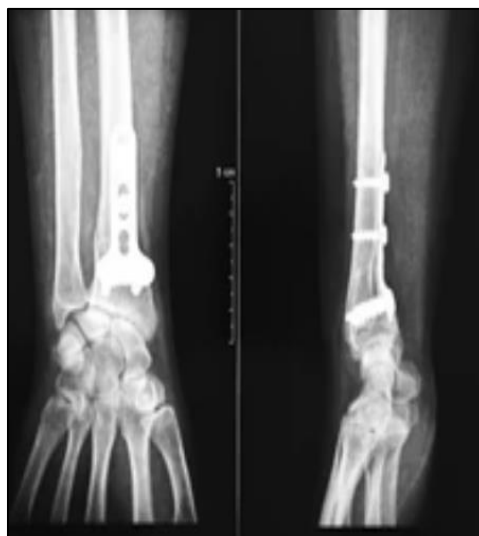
Follow-up radiographs after radius shortening and T-plate fixation [13]
